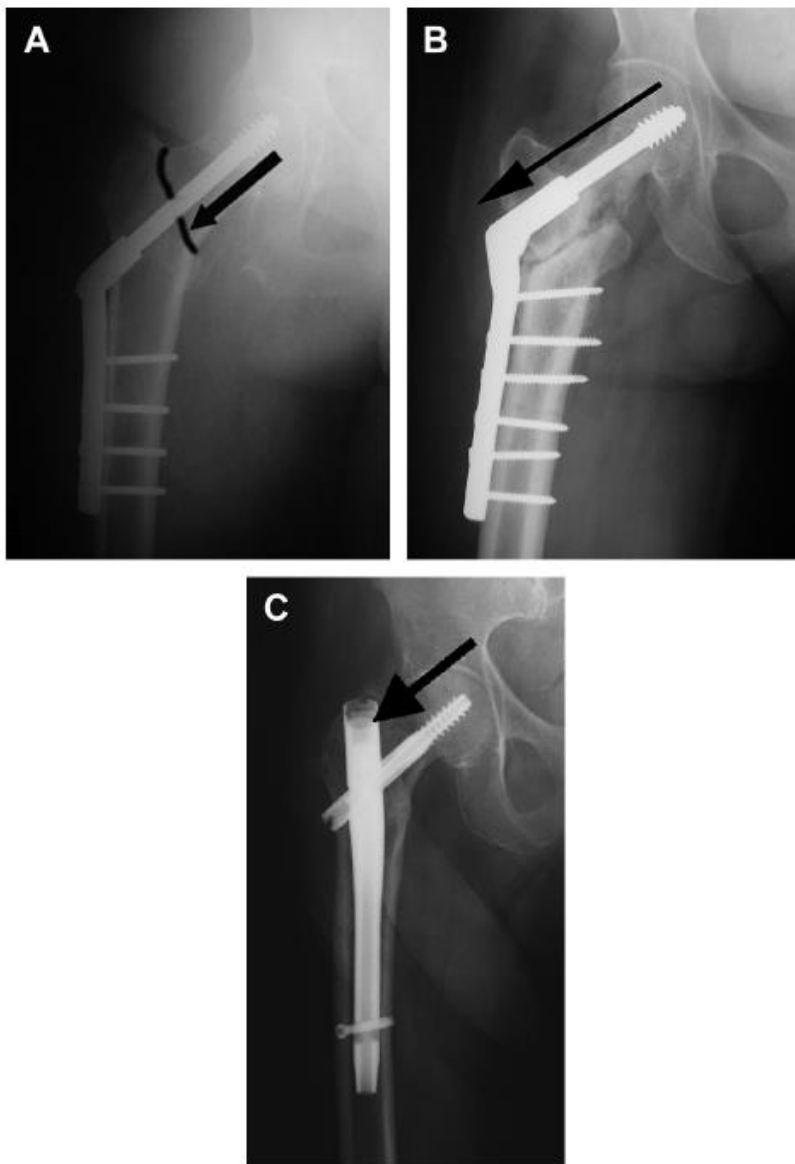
Anteroposterior radiographs showing treatment options and biomechanics for intertrochanteric fractures. (A) SHS in a stable fracture. The arrow shows the vector of force during standing. With the lateral cortex intact, the fracture can stably impact as the screw slides within the barrel of the plate. (B) SHS in an unstable fracture. In this reverse oblique pattern, the plate cannot resist the sliding force in the direction of the arrow, and the device fails before fracture healing. (C) IMHS in an unstable fracture. The fracture impacts along the path indicated by the arrow, and the nail itself acts as a limitation to the sliding of the screw.
